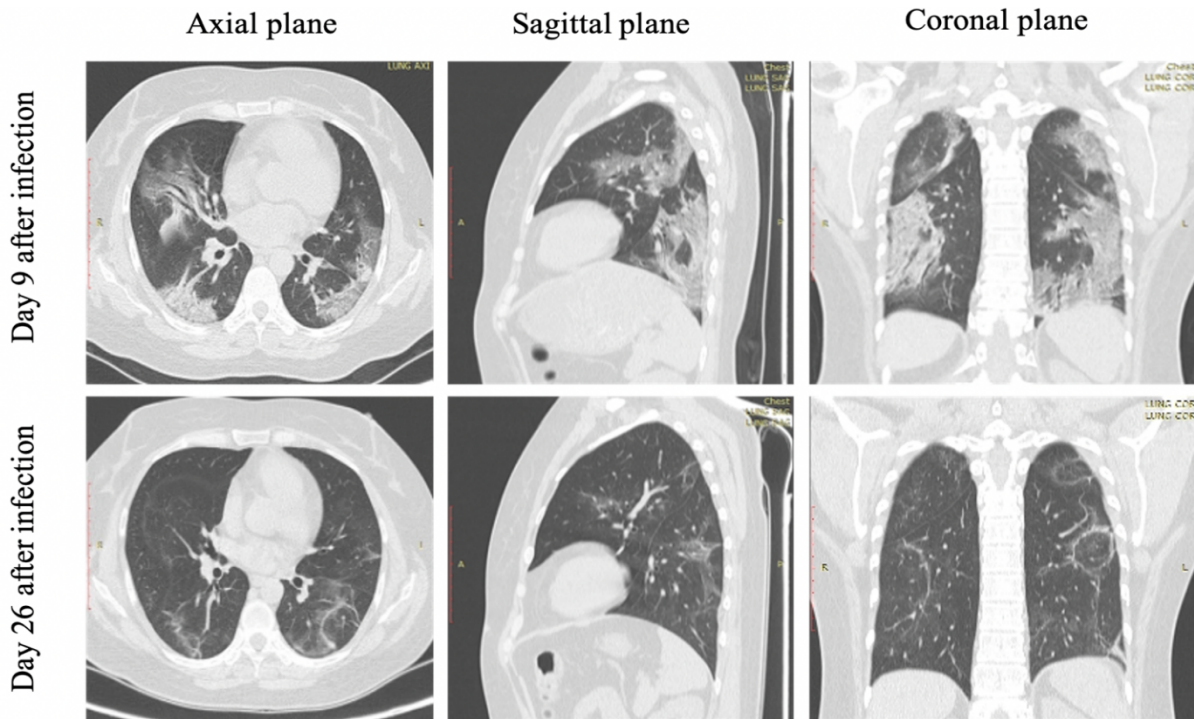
The results of CT of case 3.
